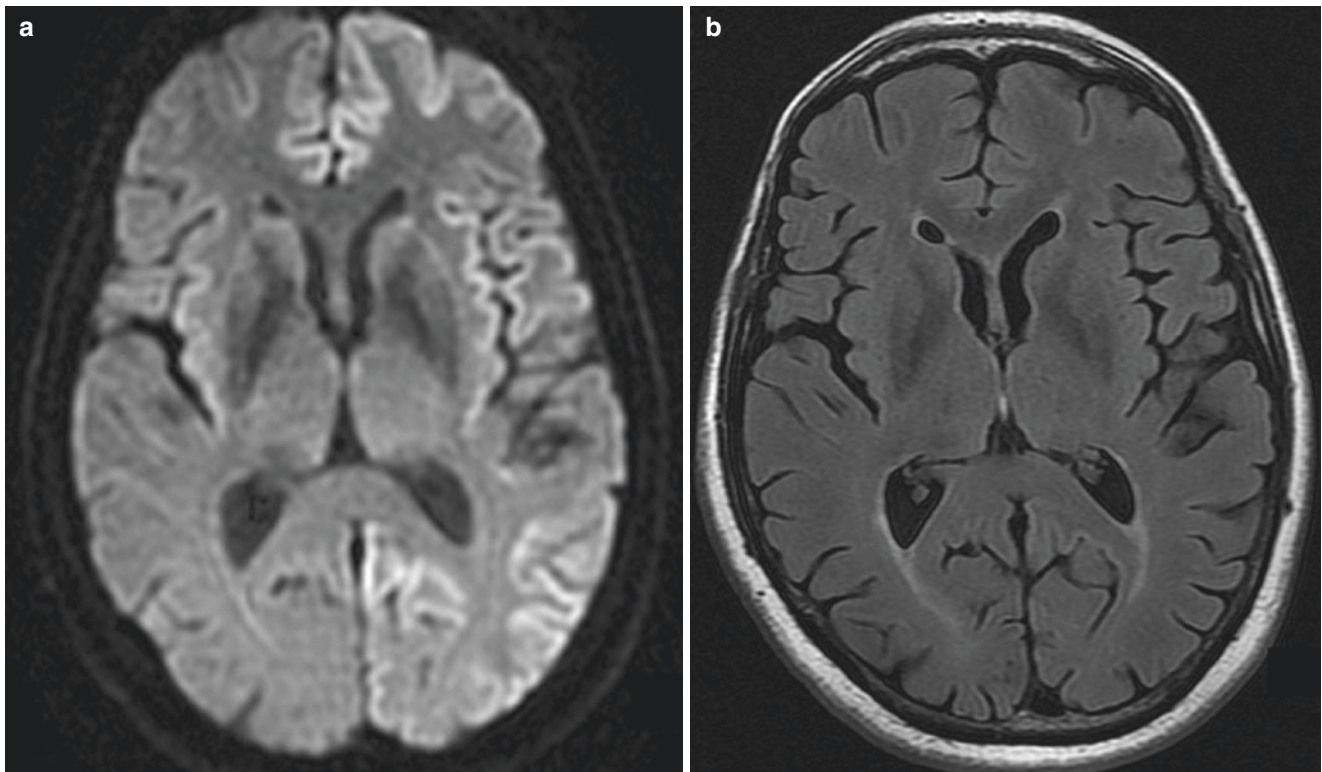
Sporadic Creutzfeldt–Jakob disease. (a), Axial DWI shows cortical diffusion restriction in the bilateral insular and cingulate gyri as well as left frontal and occipital lobes. (b), No FLAIR signal
